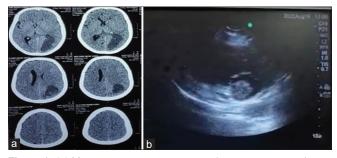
(a) Magnetic resonance imaging showing metastatic lesion in the left parieto-occipital lobes. (b) Echocardiographic finding of the left atrial thrombus
